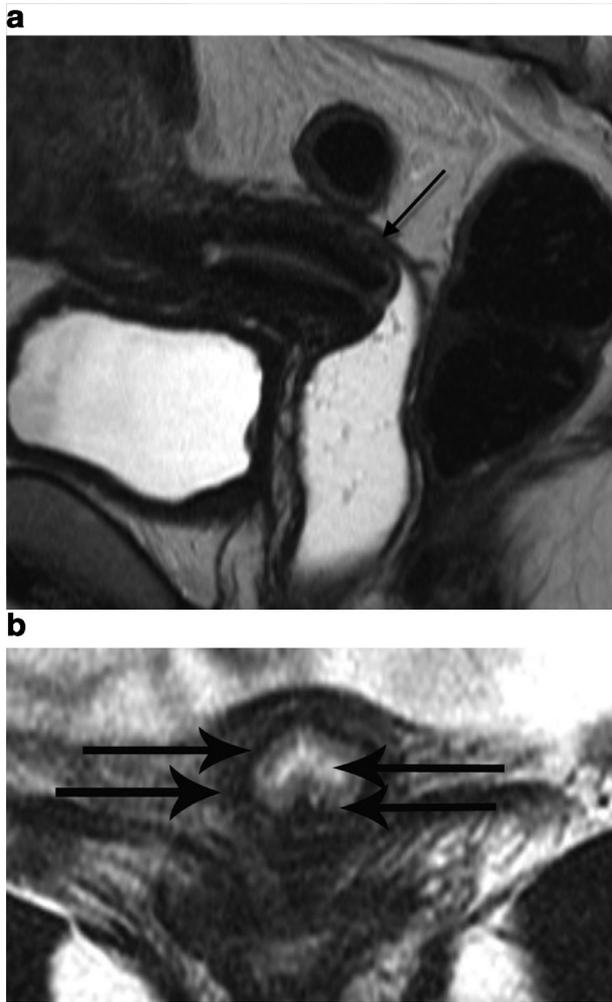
Normal cervix. (a) sagittal T2 weighted MRI of the pelvis with vaginal gel reveals normal cervix (arrow) (b) axial T2 weighted MRI of the normal cervix demonstrates normal zonal anatomy (in order from the center): high T2 signal intensity in fluid/mucus in the endocervical canal, intermediate high T2 signal intensity in columnar epithelium in the endocervix, low T2 signal intensity cervical stroma, and low-intermediate T2 signal intensity in the outer cervical stroma.
